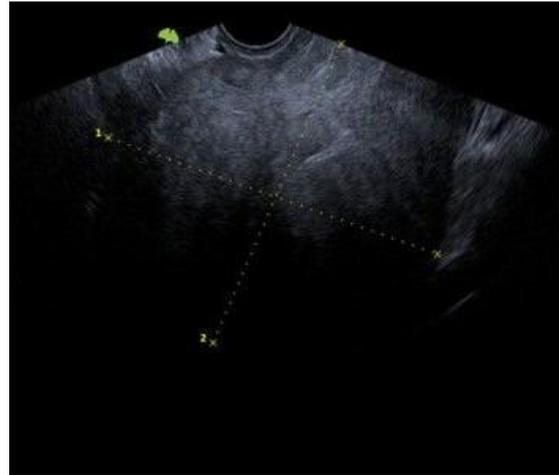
Pelvic Ultrasound reveals a large intraabdominal mass
